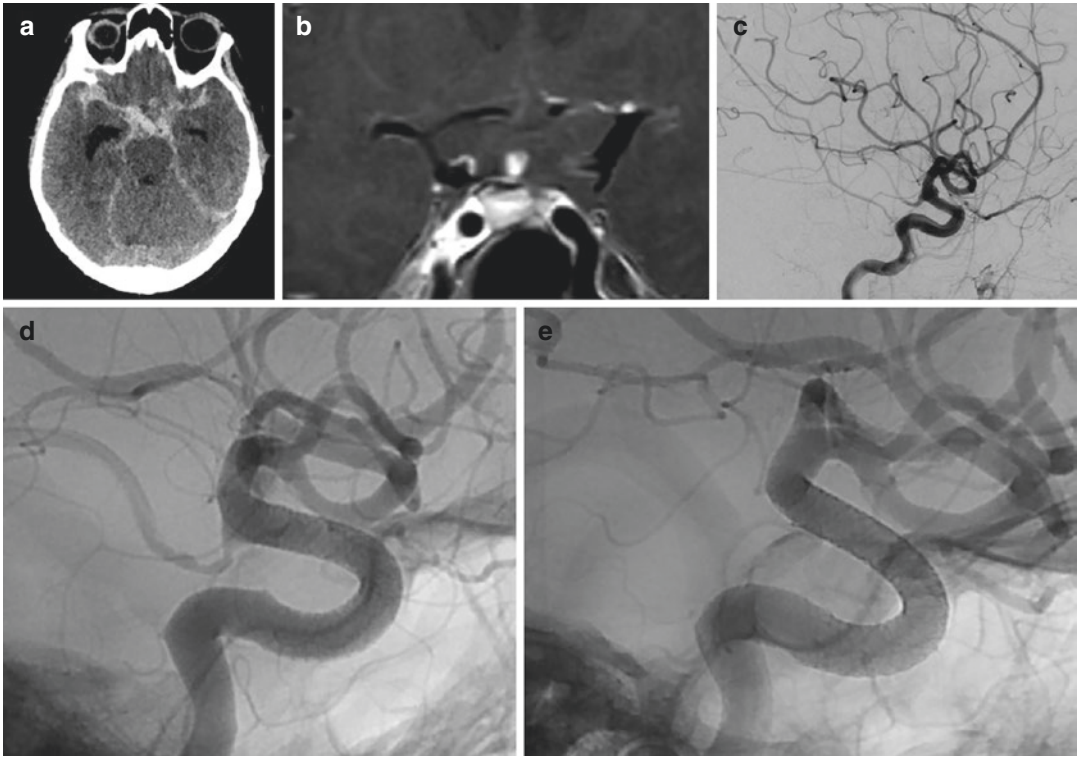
A 43 years old patient presented with mFisher IV SAH (a), CTA was considered normal and contrast-enhanced MRI showed a gadolinium uptake within an addition image of the dorsal wall of the right internal carotid artery (b). Angiogram confirmed the presence of a
